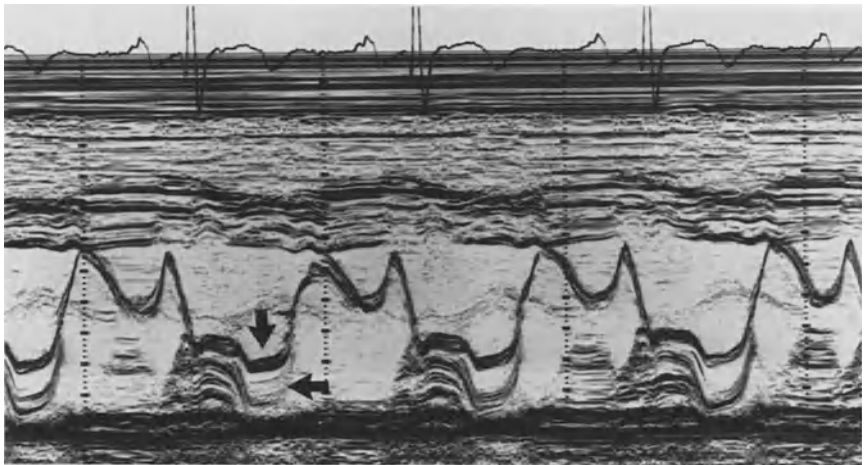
M-Mode echocardiogram of myxomatous mitral valve showing thickening and prolapse at both leaflets (arrows).
